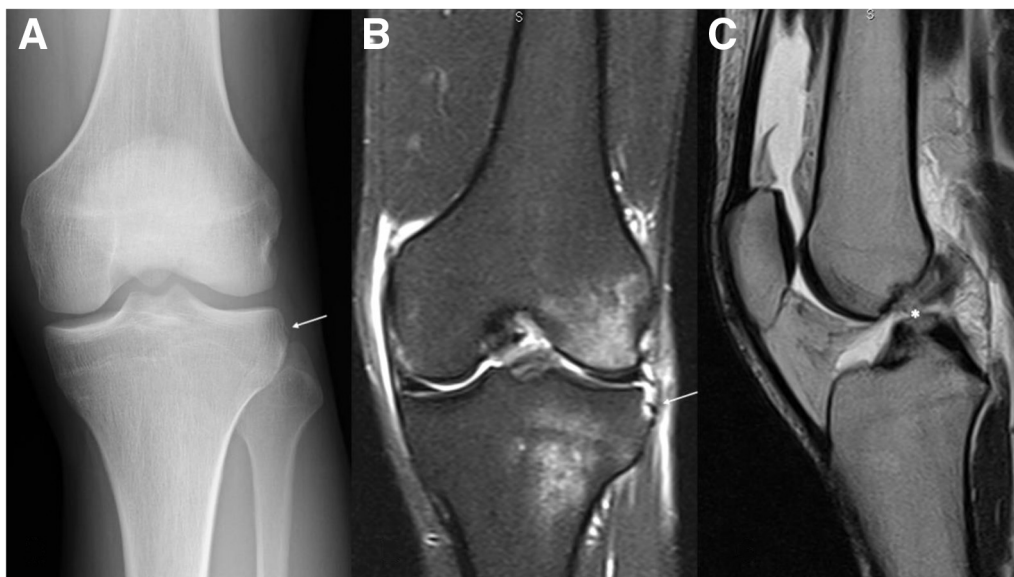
Preoperative evaluation. (A) Arrow indicates the bony fragment in the lateral tibial plateau of the left knee. (B) Arrow indicates Second fracture in magnetic resonance imaging (MRI) (T2-TSE weighted coronal view) in the same patient. (C) Asterisk (*) indicates the anterior cruciate ligaments (ACL) tears in MRI (T2-TSE weighted sagittal view). The remnant is classified as type II (according to van der List et al.¹⁴) with good quality.
